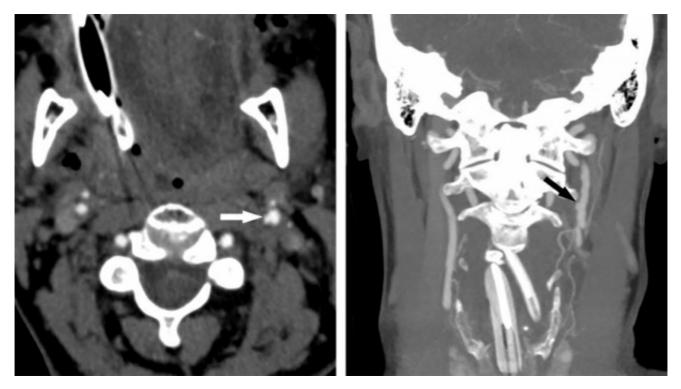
Axial (left) and coronal MIP (right) CT angiogram images through the neck in this patient after motor vehicle accident demonstrates a small focal outpouching of the left cervical internal carotid artery representing pseudoaneurysm due to vascular injury. The adjacent left internal carotid artery is also irregular and widened, suggestive of dissection.
